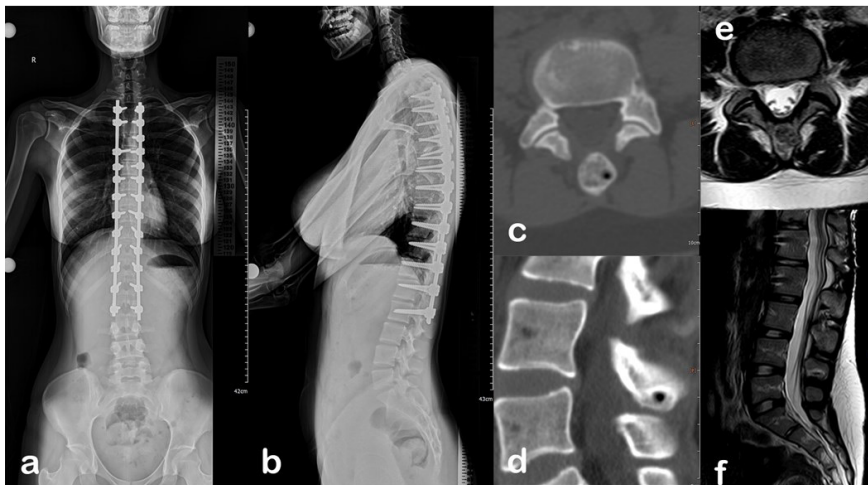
Female, 17 years old. She had complaint of back pain and operated with a diagnosis of (possibly postural) kyphosis at another center (a, b). Primary complaint of her back pain did not resolve after surgery and applied to our clinic. CT and MRI evaluation showed a benign lesion at the spinous process of L4 (c to f).
